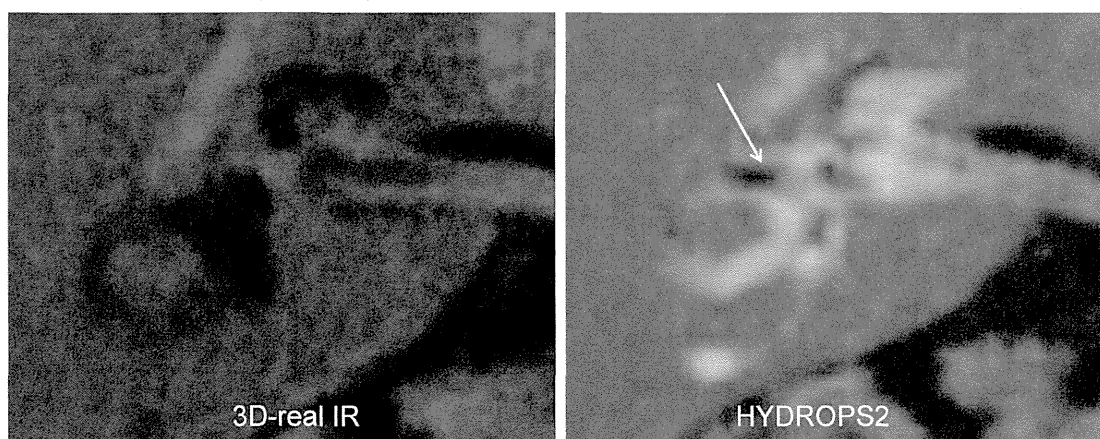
A 47-year-old man. Intravenous (IV) side. Note that enhancement of the perilymph cannot be recognized on 3-dimensional (3D)-real inversion recovery (IR). Mild endolymphatic hydrops (EH) in the vestibule (arrow) can be appreciated only on the HYDROPS2 (hybrid of reversed image of magnetic resonance cisternography and positive perilymph signal by heavily T₂-weighted 3D-fluid-attenuated inversion recovery [FLAIR]) image.
